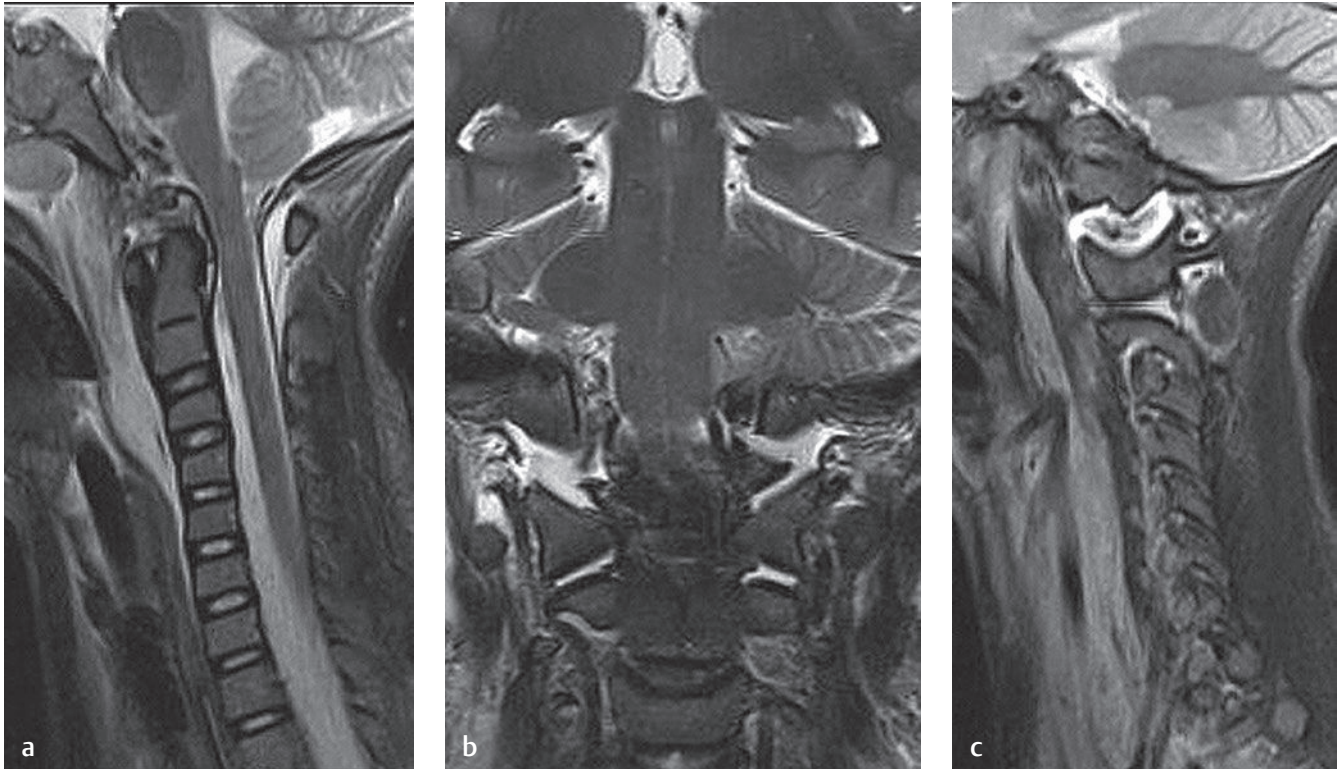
These (a) midsagittal, (b) coronal, and (c) parasagittal T2-weighted images show atlantooccipital dissociation. The midsagittal image shows an increased distance between the basion and tip of the odontoid, whereas the coronal and parasagittal images show edema in the C0-C1 joint.
